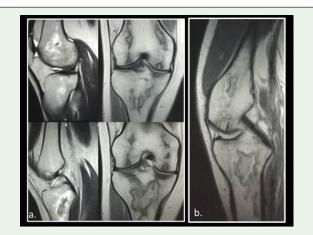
a. MRI at diagnosis, b. MRI after two years.
